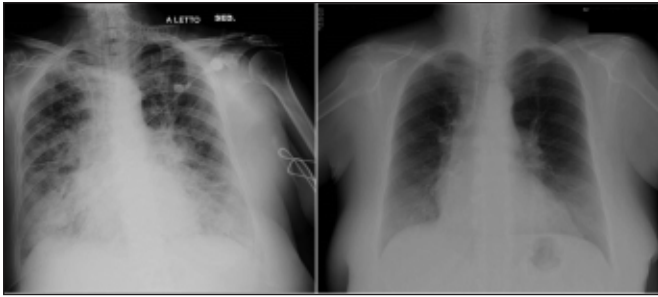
Bilateral pulmonary oedema on chest radiography (left). Normal chest radiography after 72 hours (right).
